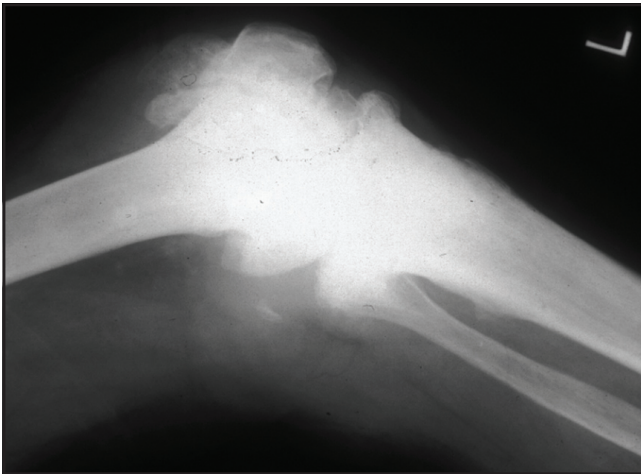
X-Ray of Charcot's Knee Joint
